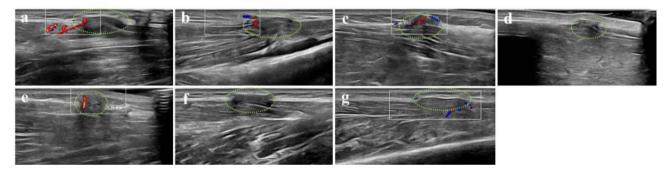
Ultrasonography findings of muscle hernias in both lower limbs. Muscle hernias a, b, c, e, and g show that blood vessels pass through the fascia, which may be the cause of the weakness of the fascia. The dotted circle is the location of the muscle hernia, and the red and blue areas in the rectangle refer to the course of blood vessels (a-g correspond to the muscle hernias of the lower limbs in Fig. 1, respectively.)
